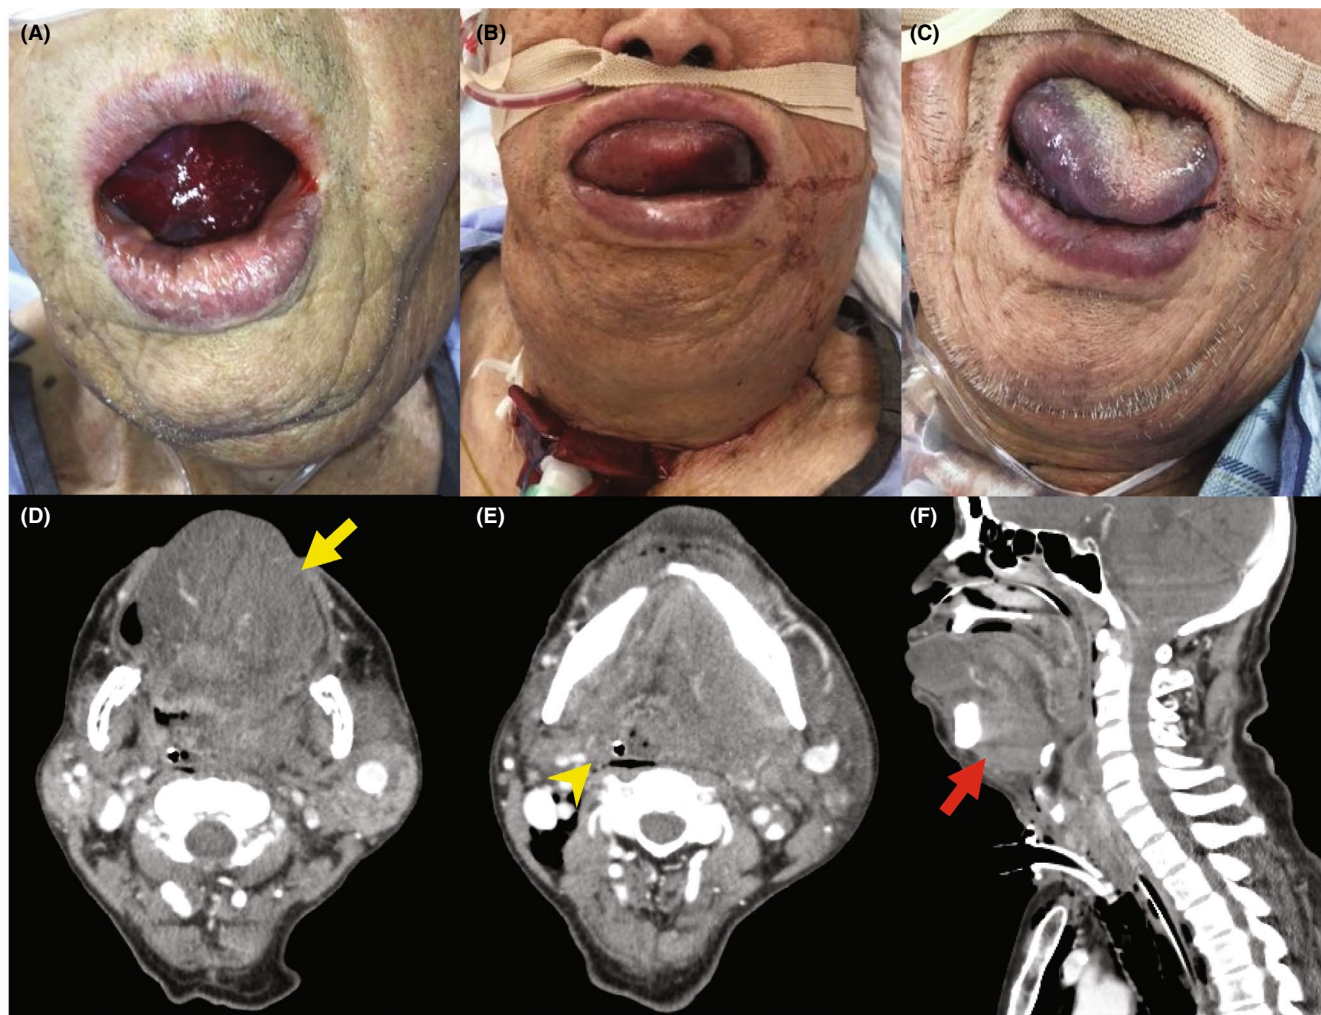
Time-series changes in the patient's tongue and neck findings. A, About 6 h after the patient took enalapril, mild swelling was observed in the tongue and neck. B, At the 20 h after taking enalapril, the swelling of the patient's tongue and neck worsened. Because of the patient's dyspnea and the inability to intubate the patient, a tracheostomy was performed. C, Angioedema improved ~72 h after the discontinuation of enalapril. D–F, CT images showing the marked edema of the tongue and soft tissue of the neck (yellow and red arrow), resulting in compression of the trachea (yellow arrowhead)
